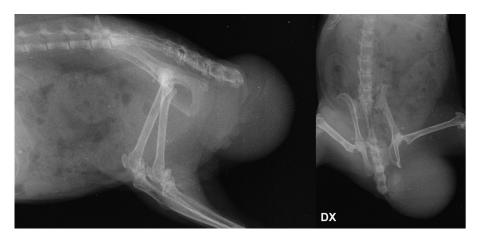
Lateral and ventrodorsal body radiographs. Tumorous mass of soft tissue radioopacity is present in the vicinity of the anus
